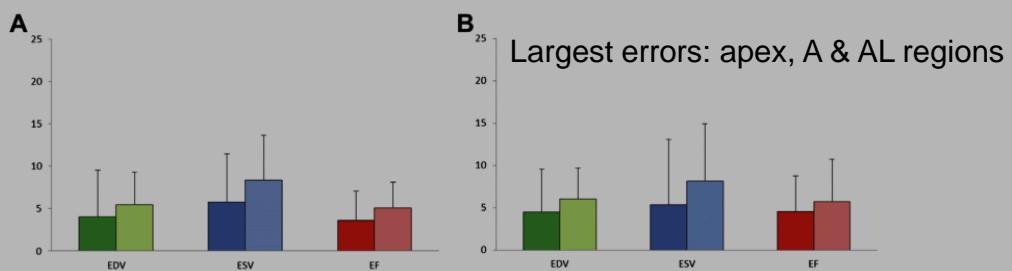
Intraobserver (A) and interobserver (B) variability of EDV (green), ESV (blue), and LVEF (red) measurements assessed by analyzing 3D echocardiographic data using 3DE_A software (full color) and 3DE_B (transparent color).
